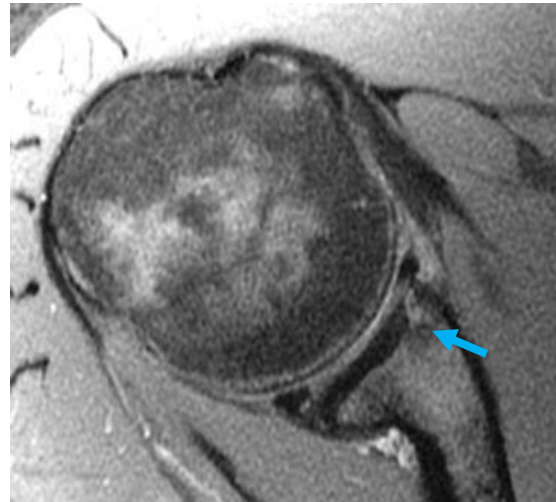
MRI of Patient B shows the bony integrity to be maintained without cyst formation.
